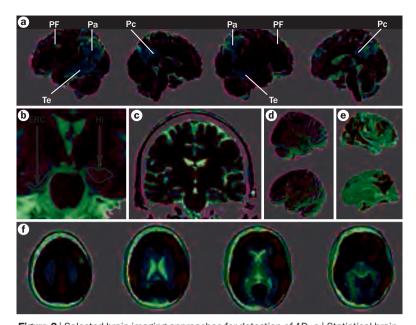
Selected brain imaging approaches for detection of AD. a | Statistical brain maps from FDG PET imaging show characteristic and progressive declines in regional CMRgl (blue) in various cortical regions in AD dementia compared with controls. b | Structural MRI studies find brain shrinkage in AD dementia, including accelerated rates of atrophy in hippocampus and ERC; c | accelerated rates of whole-brain atrophy using sequential MRI scans (red); d | characteristic and progressive loss of grey matter (red), as shown in statistical brain map comparing AD dementia with controls; and e | characteristic and progressive cortical thinning (yellow and red), as shown in statistical brain map comparing AD dementia with controls. f | Statistical comparison of PiB PET measurements of fibrillar amyloid-β show increased brain amyloid load in AD dementia compared with controls; other radioligands for fibrillar amyloid-\(\beta \) PET imaging are now under investigation. Abbreviations: AD, Alzheimer disease; CMRgl, cerebral metabolic rate for glucose; ERC, entorhinal cortex; FDG, fluorodeoxyglucose; Hi, hippocampus; Pa, parietal; Pc, precuneus; PF, prefrontal; PiB, Pittsburgh compound B; Te, temporal. Part a reproduced with permission from Massachusetts Medical Society © Reiman, E. M. et al. NEJM 334, 752-758 (1996). Part d reproduced with permission from Elsevier Ltd @ Baron, J. C. et al. Neuroimage 14. 298-309 (2011). Part e reproduced with permission from Oxford University Press © Du, A. T. et al. Brain 130, 1159-1166 (2007).
